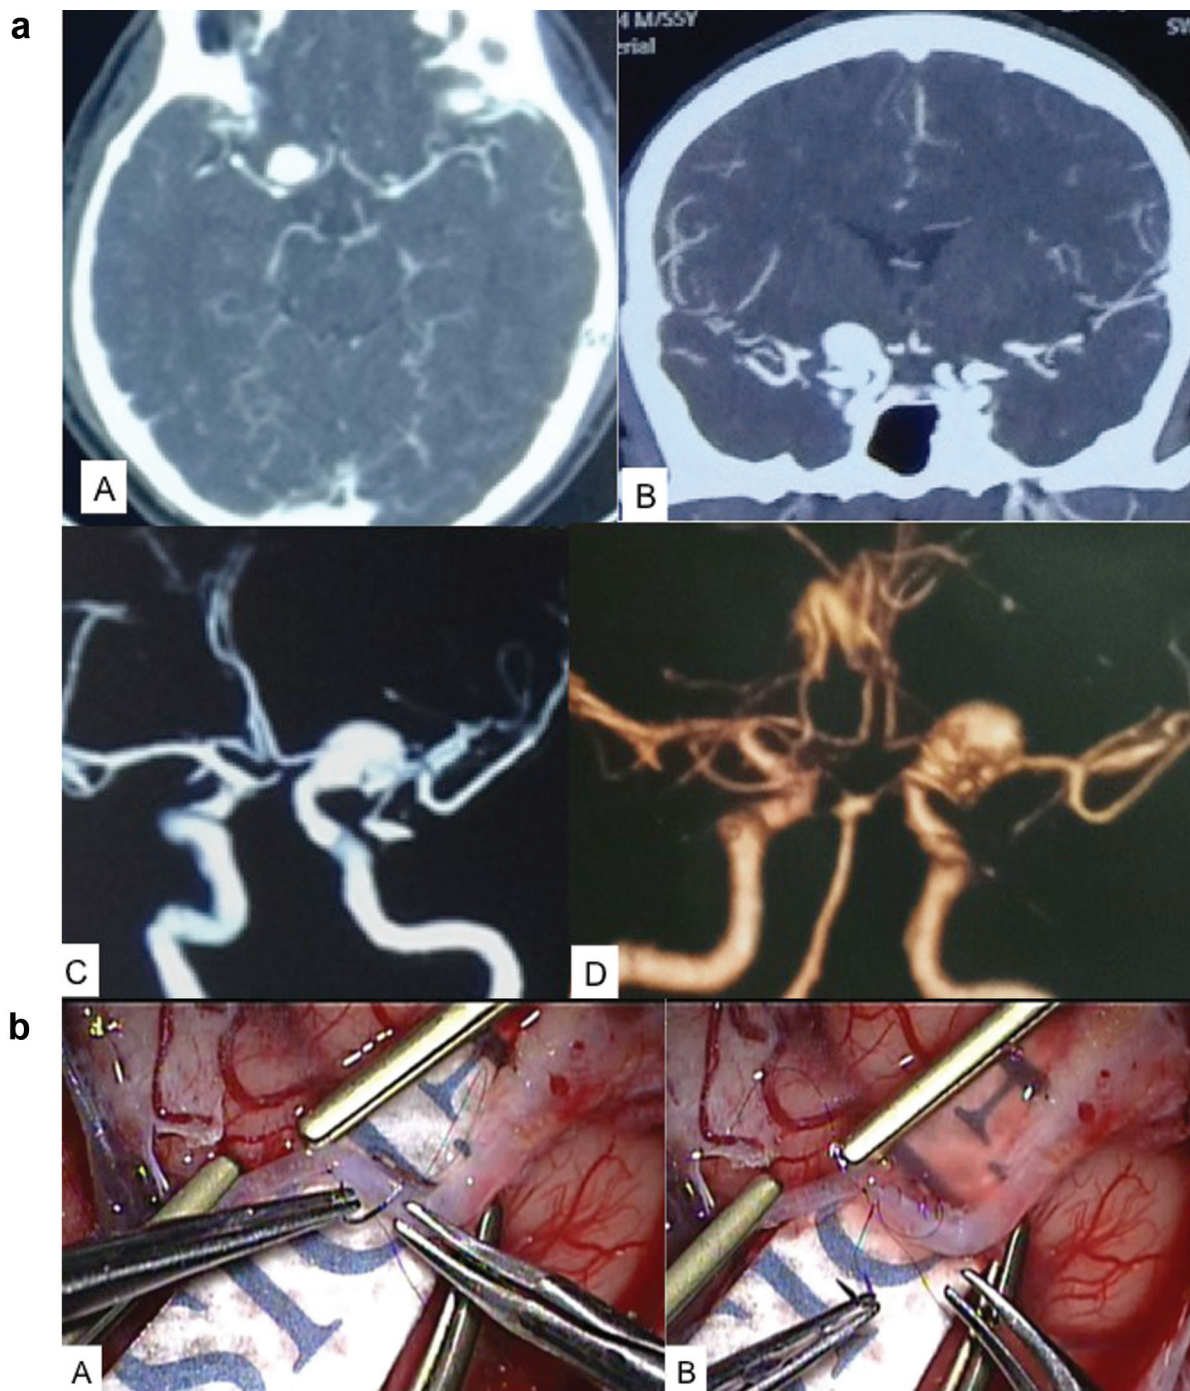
(a): (A, B, C & D) CTA of the brain showing a large fusiform aneurysm involving the left supraclinoidal ICA. (b): (A & B) preoperative pictures of insurance STA-MCA bypass before performance of EC-IC high flow bypass. (c): (A & B) preoperative pictures; sylvian dissection, identification and preparation of the temporal M2 as recipient artery for anastomosis with radial artery (RA) graft. RA, radial artery; M2 (MCA). (d): A & B-preoperative pictures of RA and M2 anastomosis. (e): A & B preoperative pictures of RA and CCA anastomosis. (f): Postoperative CTA of the brain and neck vessel on the 2nd POD showing CCA-RA-M2 high flow EC-IC bypass and nonvisualization of the left supraclinoidal ICA aneurysm.
